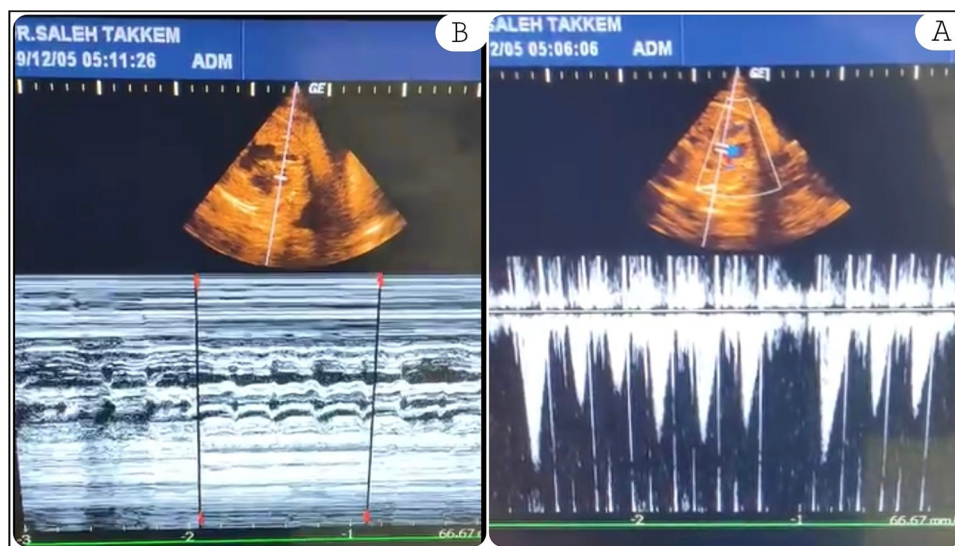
(A) Doppler imaging of the left ventricular outlet in the fetus shows irregular waves consistent with responsive atrial flutter with altered transmission. (B) M-mode image showing the speed of atrial flutter.
